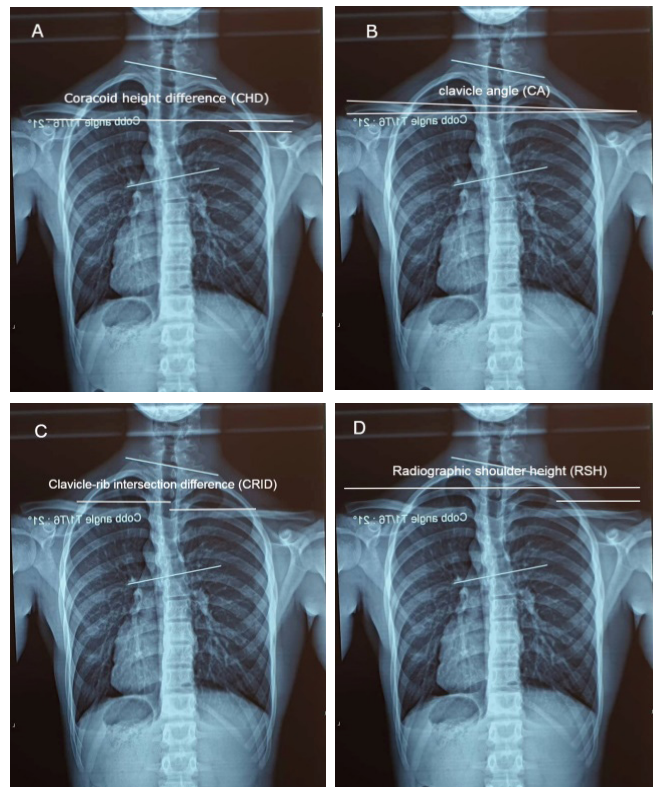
Lateral shoulder imbalance radiographic parameters. A, Coracoid height difference (CHD). B, Clavicle angle (CA). C, Clavicle-rib intersection difference (CRID). D, Radiographic shoulder height (RSH).
